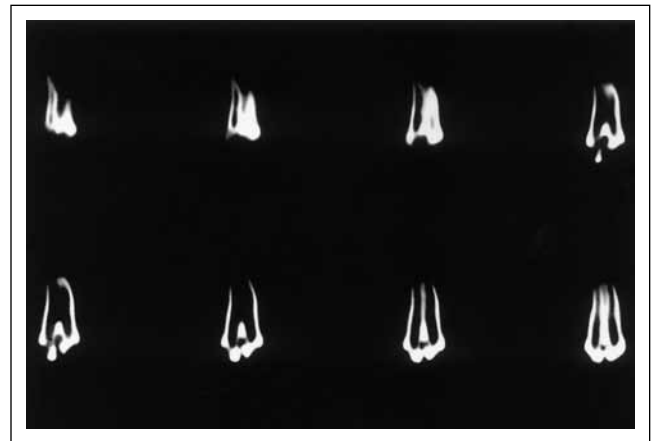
Longitudinal axial CT images. Internally, is evident an almost total joining of the root canals at the mid-level of the root like a large tooth structure with a large root canal.
